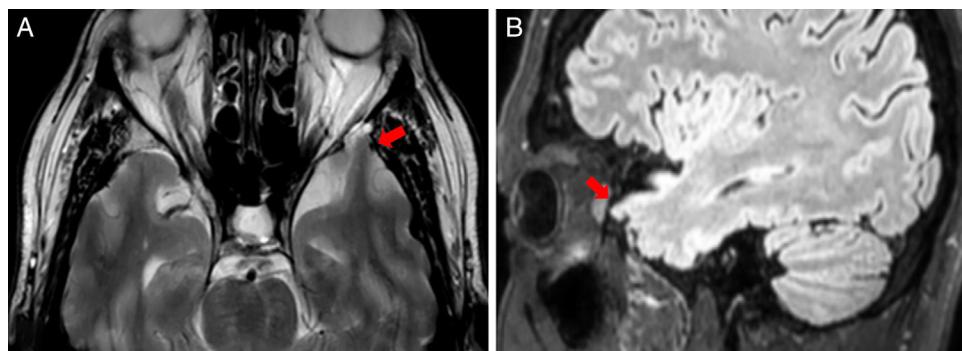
MRI scan: axial T2-weighted (A) and sagittal T2-weighted FLAIR sequences (B), showing a small herniation of the brain parenchyma in the anterior pole of the left temporal lobe through an anterior bone defect on the base of the cranium; this finding suggests encephalocele.
